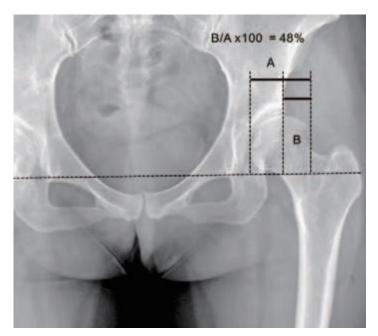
Representative technique for calculating the femoral head extrusion index. (SJ Lim, Plain Radiography of the Hip: A Review of the Radiographic Techniques and Image Features. 2015)
